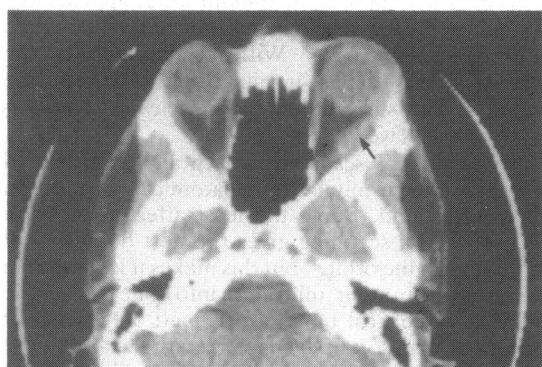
CT scan of case 1 showing enlargement of right lateral rectus muscle (arrow). The fusiform shape is not very obvious and the outlines are not clearly defined.
